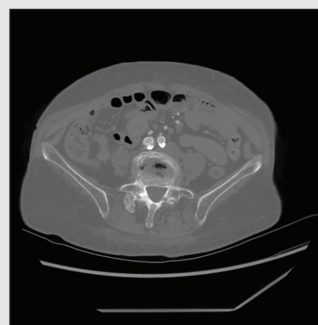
Postintervention CTA demonstrating patent aortic and bilateral CIA stents.
